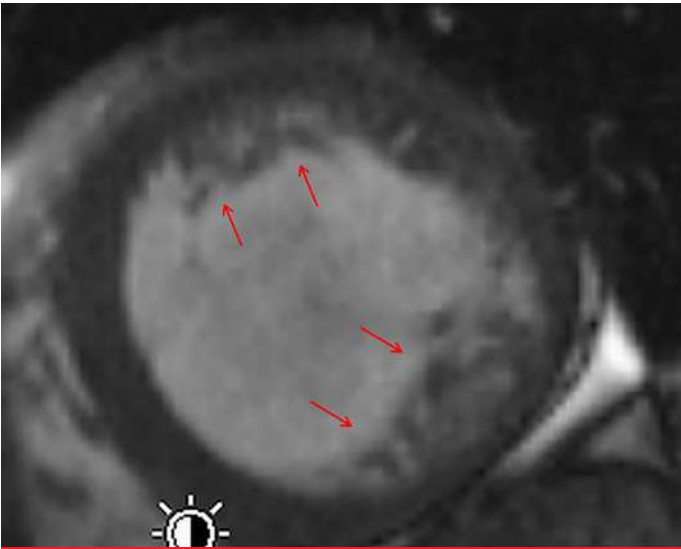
cMRI of a female carrier of a dystrophin deletion showing extensive left ventricular hypertrabeculation in the short axis view. cMRI, cardiac MRI.
